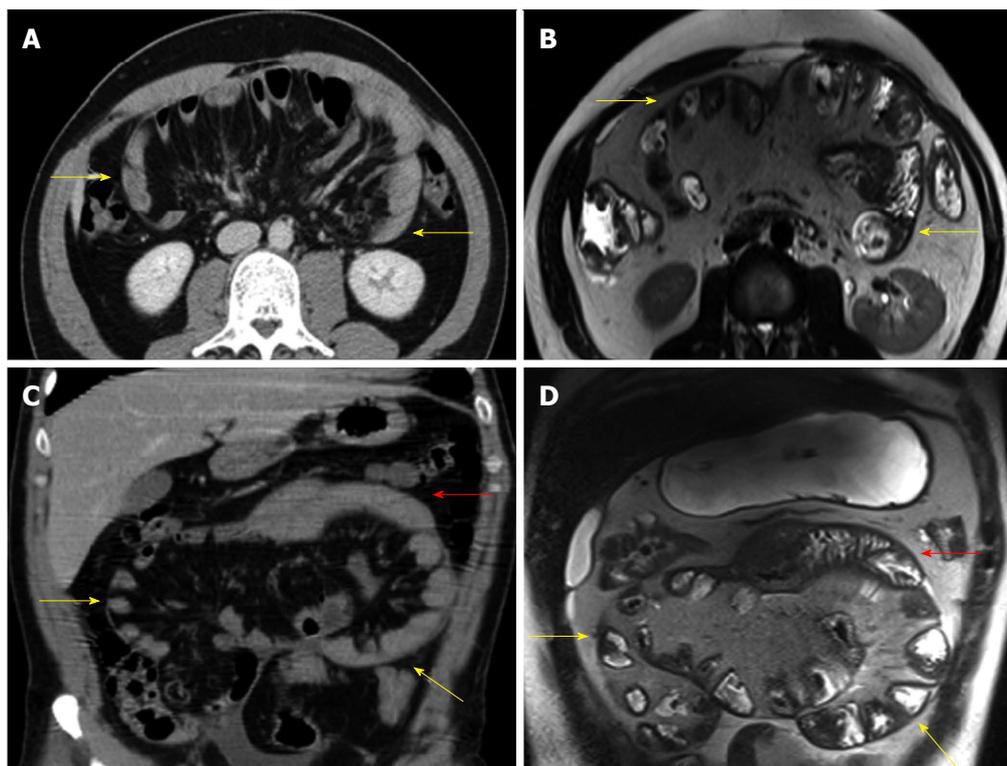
Comparison of diagnostic features on computed tomography and magnetic resonance images^[9]. A: Computed tomography scan in the axial plane showing a subtotal conglomeration of small bowel loops coiled in a concertina-like fashion and encased by a thick membrane (yellow arrows); B: T2-weighted magnetic resonance imaging sequence in the axial plane showing bowel loops aggregated in a festoon-like shape and encased by a thick membrane (yellow arrows); C: Computed tomography scan in the coronal plane showing the conglomeration of small bowel loops (yellow arrows); a few free loops are present in the upper quadrant (red arrow); D: T2-weighted magnetic resonance imaging sequence in the coronal plane showing the same conglomeration of small bowel loops (yellow arrows) and a few free bowel loops (red arrow).
